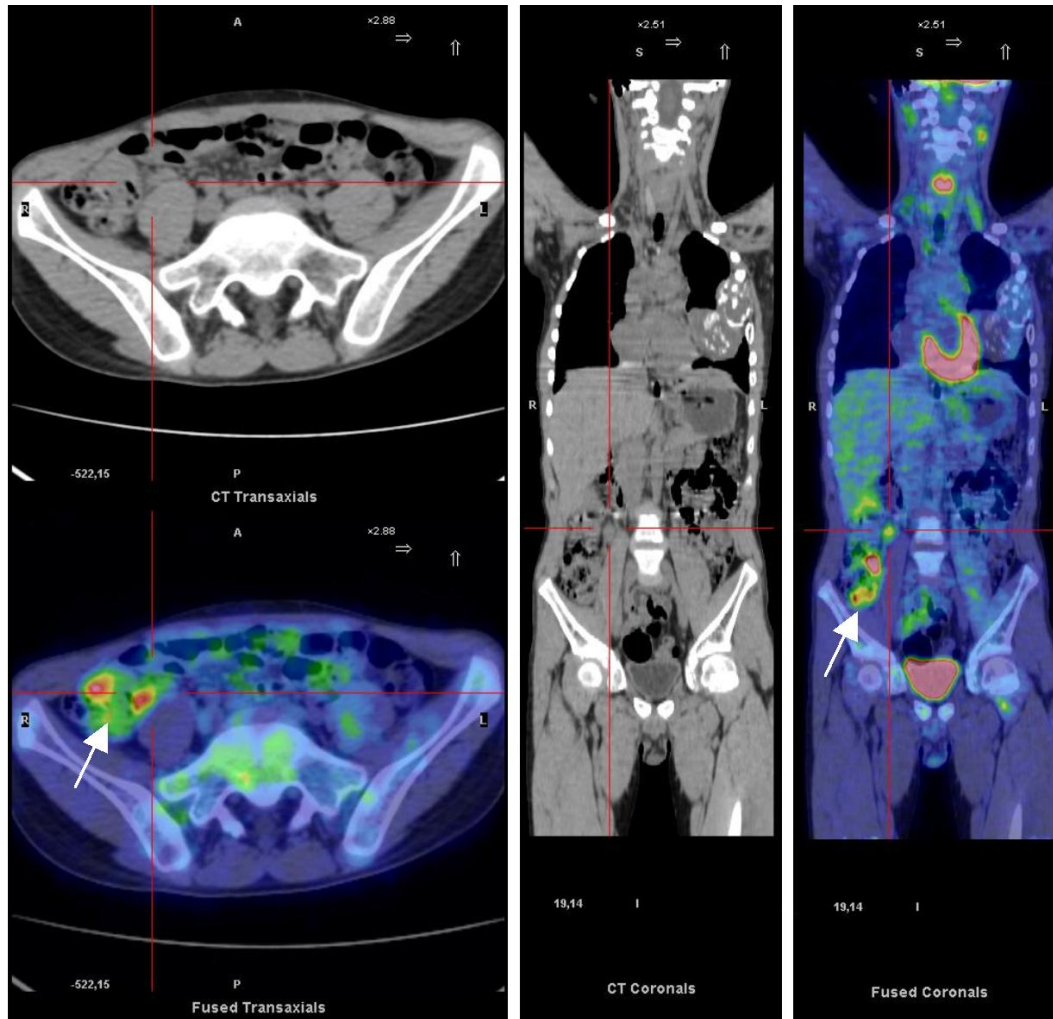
18F-FDGPET/CT images (transaxial and coronal slides) in a patient with active CD. Images show areas with increased glucose metabolism. A reactive lymphonode is detectable (defined by red lines) but not necessarily it is an infected site. White arrow shows activity in the inflamed gut wall and because of lack of specificity of the radiopharmaceutical, these areas can be inflamed or infected.*
